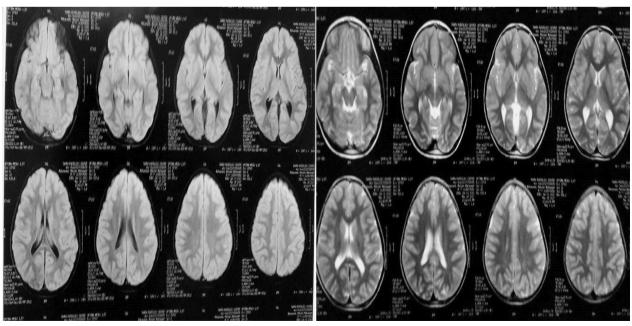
MRI brain displayed infratentorial brain involution with a small infarction in the left cerebral hemisphere with cerebellar hypoplasia
